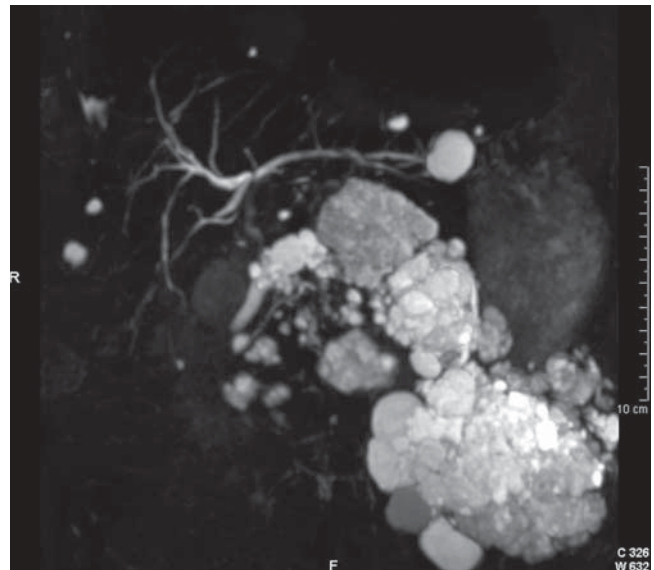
MR image (T2-weighted), performed at 3-year follow-up, showing the absence of noticeable tumor growth. Lesions in the head are particularly well discernible on this image
